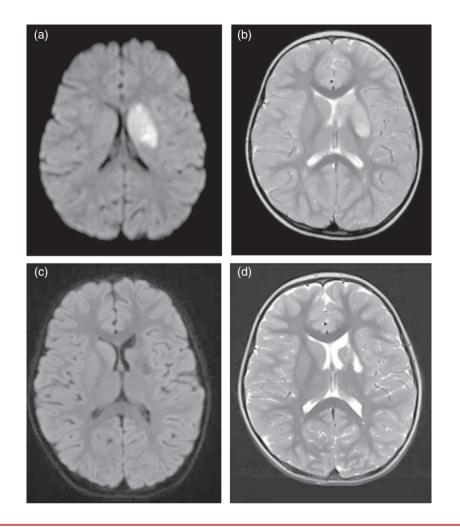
Acute (a,b) and chronic (c,d) brain magnetic resonance imaging after arterial ischemic stroke (AIS) in middle cerebral artery (MCA) territory at 3 years old. Acute changes on axial diffusion-weighted imaging (DWI) (a) and axial T2-weighted imaging (b), involving the left putamen and caudate nuclei (MCA territory). Brain imaging from the same patient at 2-year follow-up depicting the chronic evolution of AIS, with free diffusion on DWI (i.e. absent hyperintense signal [c] and atrophy on T2-weighted imaging [d]).
